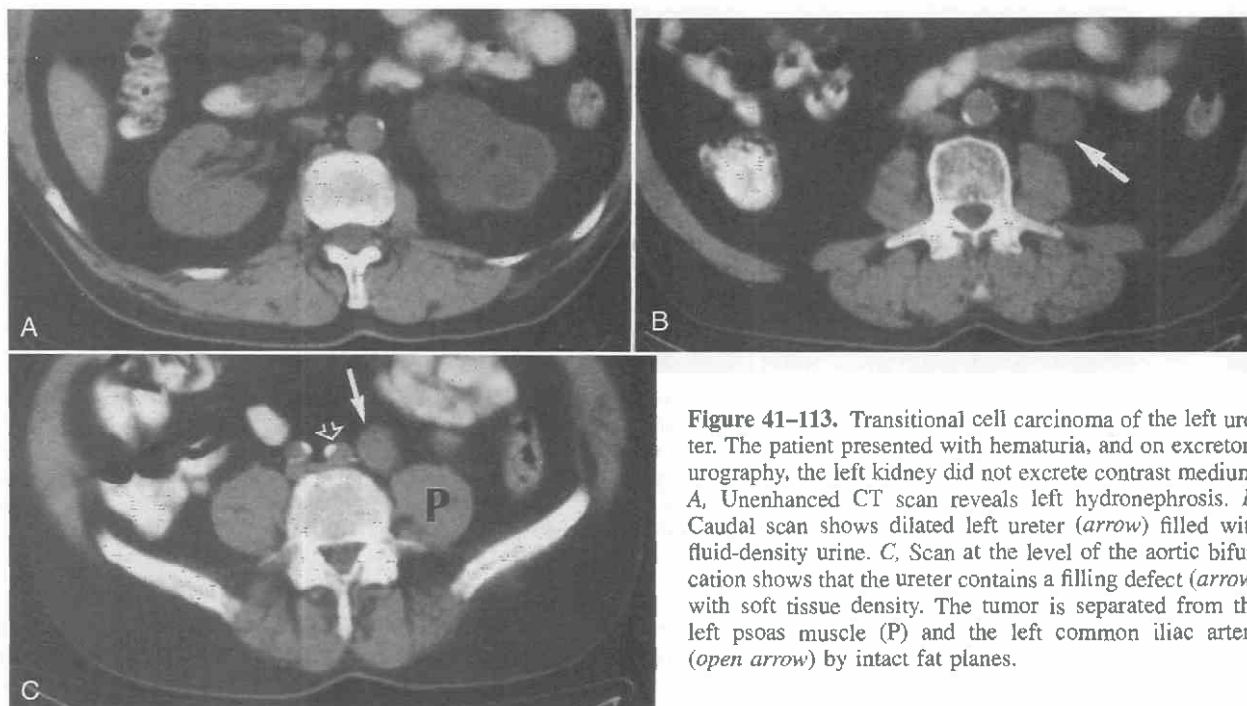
Transitional cell carcinoma of the left ureter. The patient presented with hematuria, and on excretory urography, the left kidney did not excrete contrast medium. A, Unenhanced CT scan reveals left hydronephrosis. B, Caudal scan shows dilated left ureter (arrow) filled with fluid-density urine. C, Scan at the level of the aortic bifurcation shows that the ureter contains a filling defect (arrow) with soft tissue density. The tumor is separated from the left psoas muscle (P) and the left common iliac artery (open arrow) by intact fat planes.
